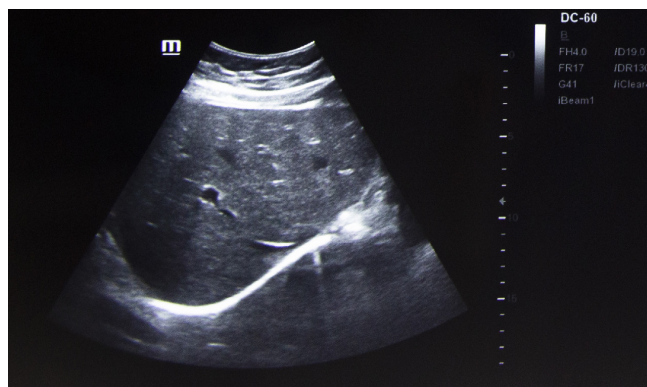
Ultrasonographic image showing complete resolution of tubercular liver abscess.
